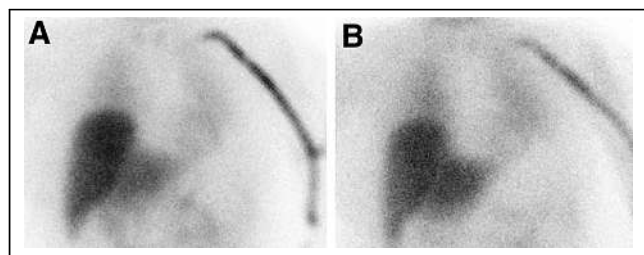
Early (A) and delayed (B) cardiac ^{123}I -MIBG scintigraphy images interpreted as borderline by one reporter and abnormal by second reporter on visual assessment. After addition of HM ratios of 1.78 and 1.58, respectively, both reporters interpreted study as abnormal.
